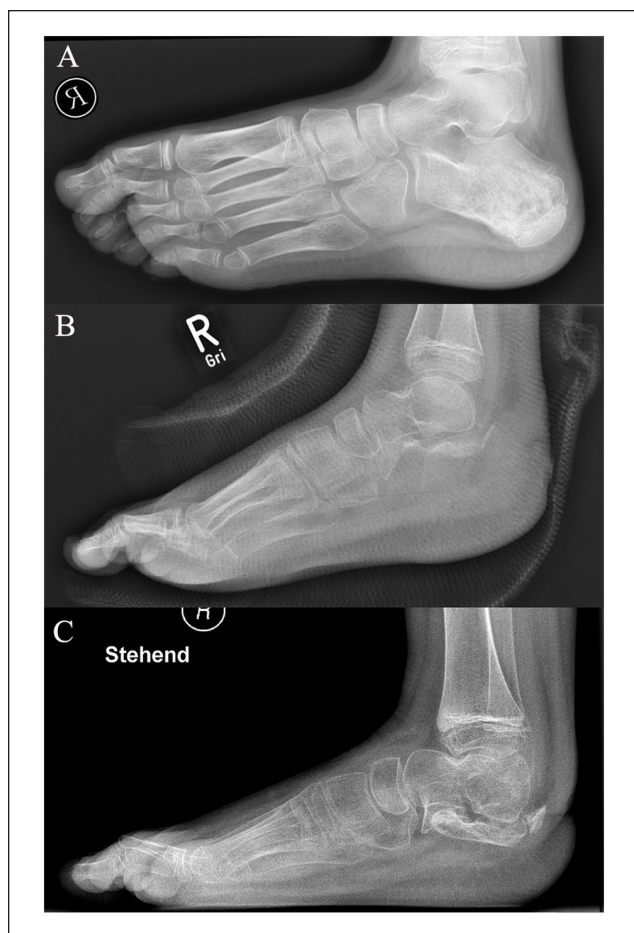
Radiologic follow-up in a 9-year-old patient with Ewing sarcoma of the calcaneus who underwent subtotal calcaneotomy without reconstruction and transposition of the Achilles tendon to the posterior talar process: (A) preoperative, (B) 3 days postoperative, and (C) 10 months postoperative radiographs.
